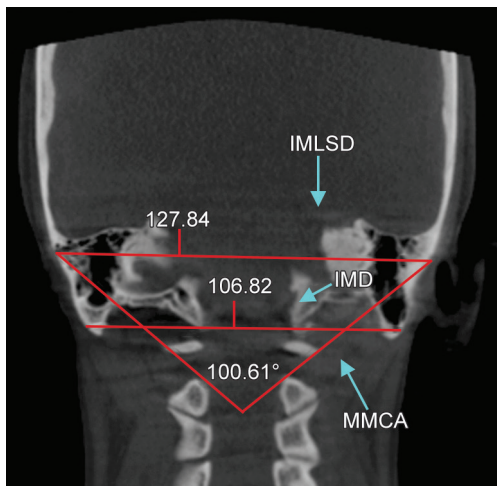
CBCT image: Measurement of intermastoidale distance (IMD), intermastoidale lateral surface distance (IMLSD), and mastoid medial convergence angle (MMCA)
